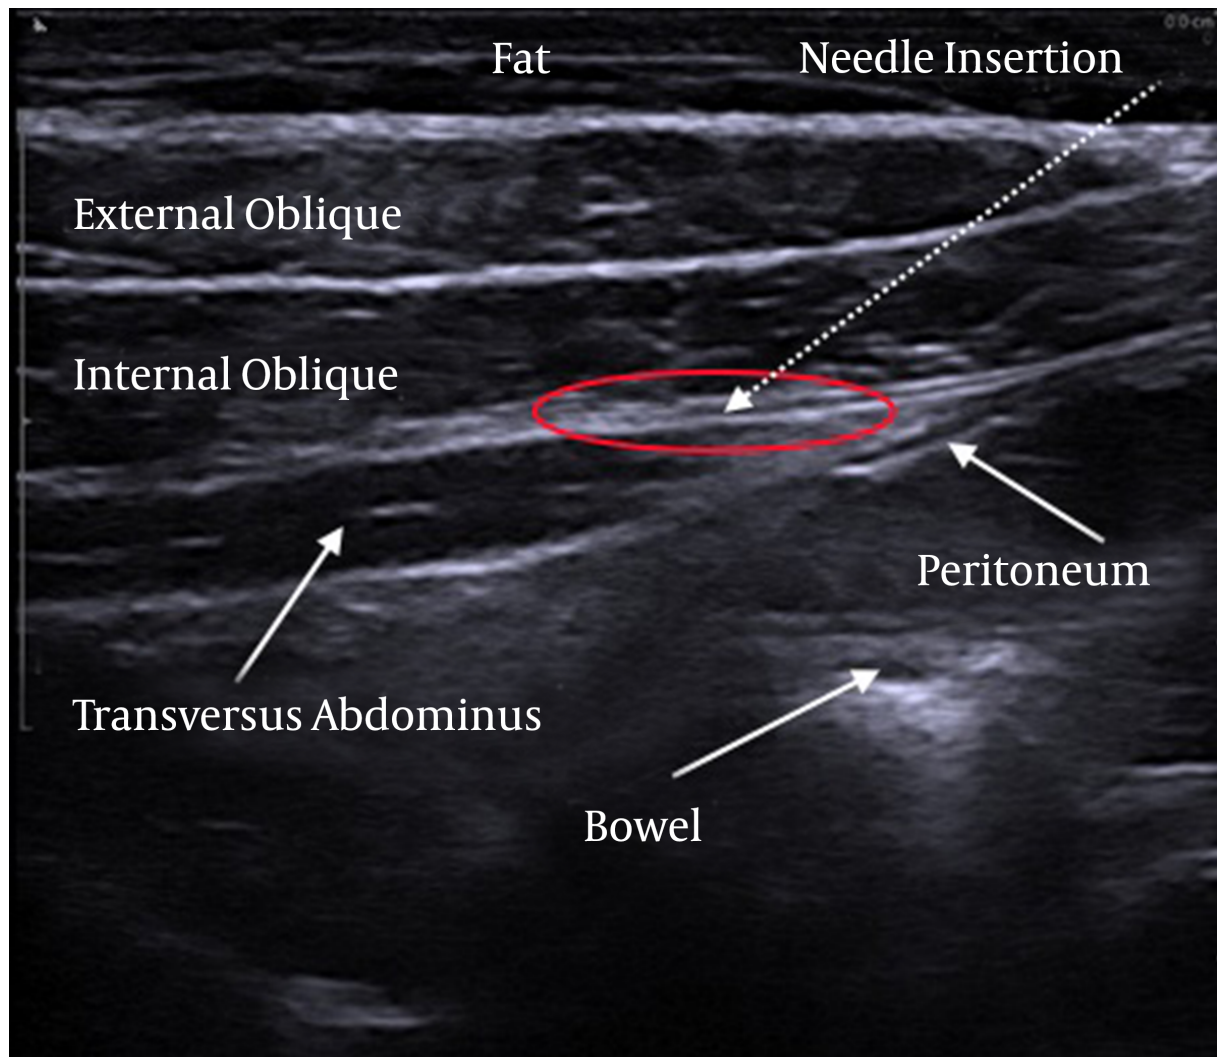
Ultrasound Representation of the Abdominal Wall Muscles and Needle Insertion to Accomplish a Transversus Abdominis Plane Block
